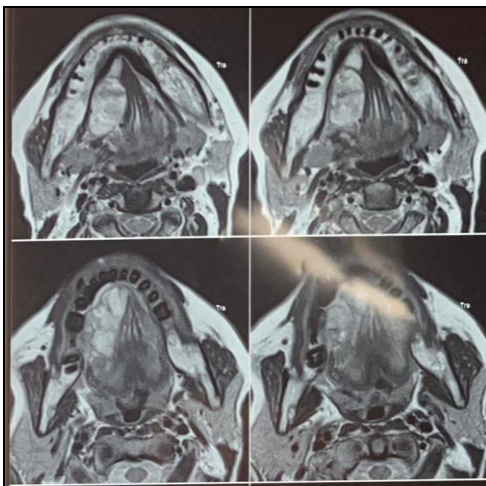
Axial MRI demonstrating the tumor's extent in the floor of the mouth with close relation to adjacent muscles and submandibular glands, without obvious bony invasion.
